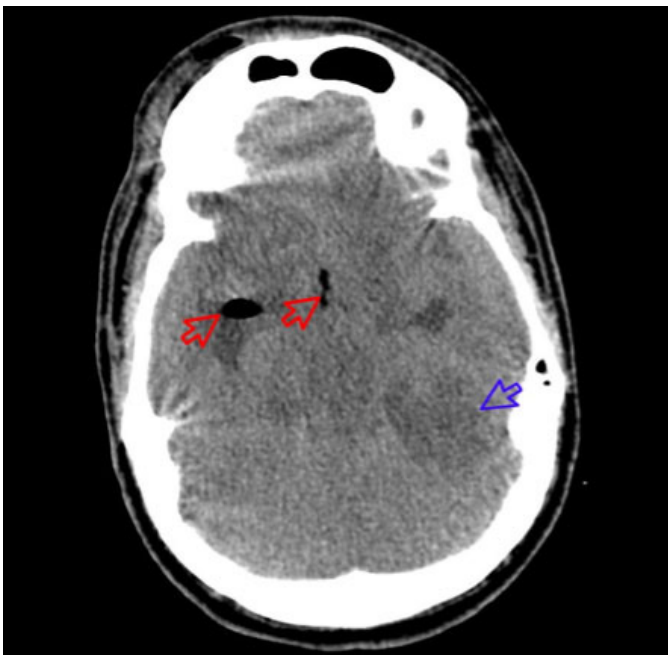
Control head CT scan showing signs of intracranial hypertension and cortical-medullar ischemia.
